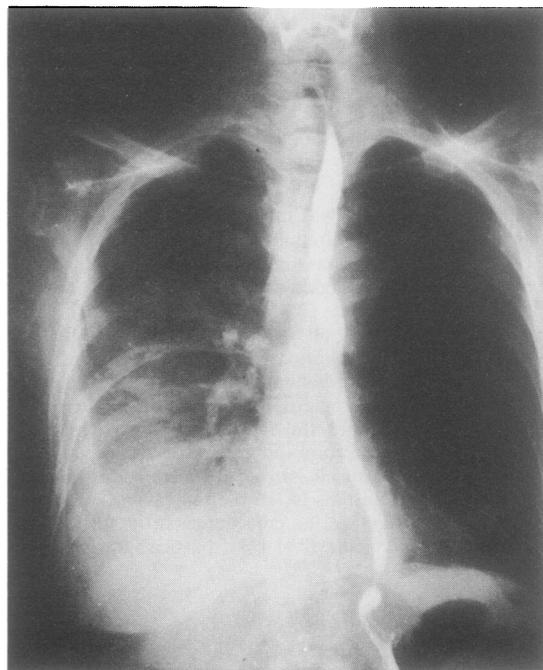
Chest radiograph and barium swallow showing a right haemothorax and displacement of the lower oesophagus to the left, with a normal mucosal profile.
